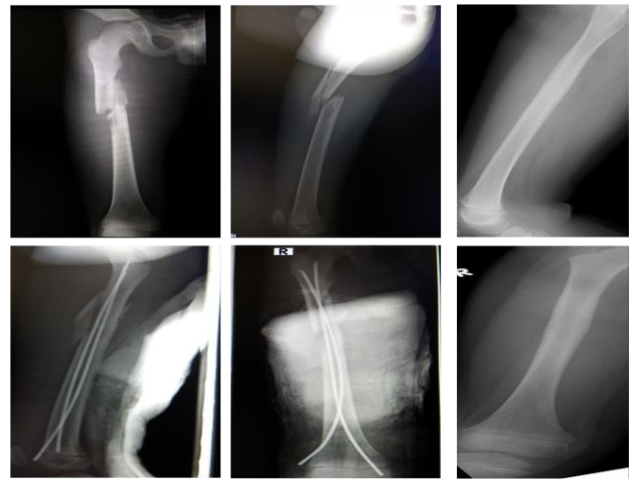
Pre- and post-operative X-ray femur.
